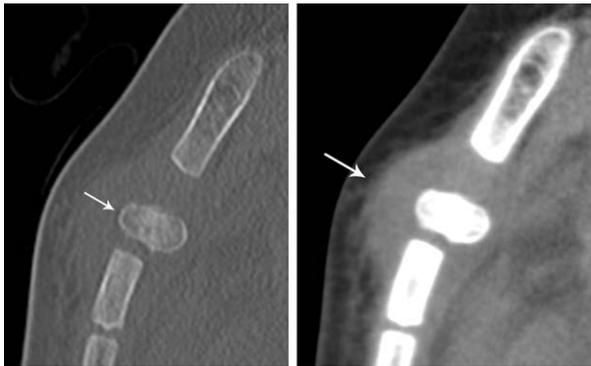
Sagittal CT reconstruction of the sternum in bone (A) and soft tissue windows (B) shows dislocation with 90° rotation of the first sternal segment (arrow). There is also a nondisplaced fracture line with cortical irregularity in the middle portion of the first sternal segment.
